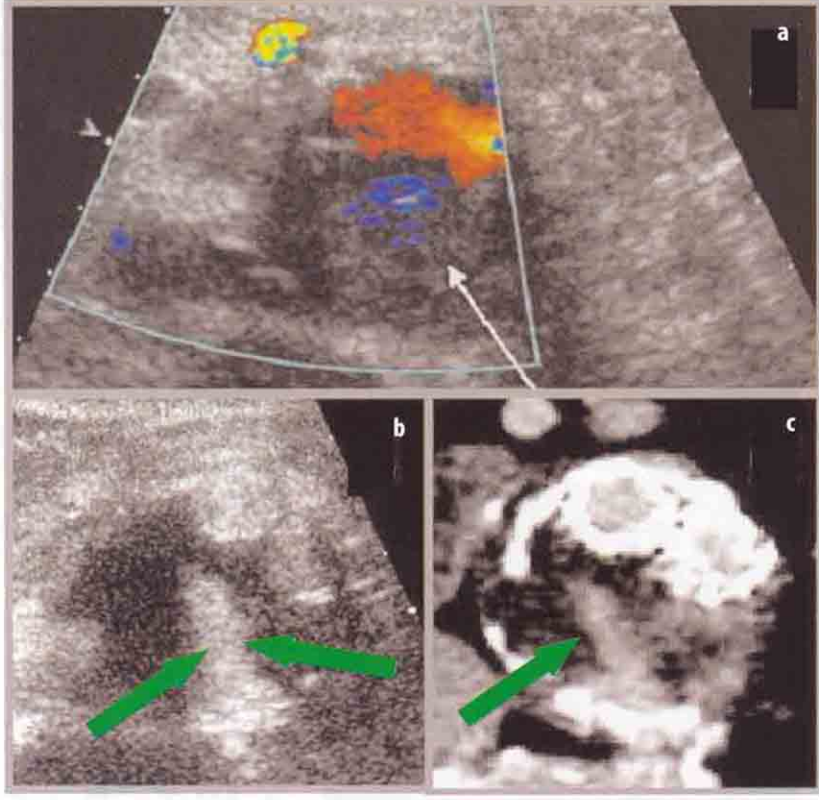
Type II Endoleak. a Transversal scan, colour Doppler. The aorto-iliac endovascular graft in the anterior part of the aneurysm is correctly patent; posteriorly, inside the residual thrombosed aneurysmatic sac, there is a chromatic signal (blue) (white arrow), which is not easily interpretable (possibly flow or artefact?). b Same, CEUS scans. In longitudinal (c) scan, the graft lumen is patent (hyperechoic); inside the residual sac, posteriorly to endoprosthesis a thin, hyperechoic, winding flow lumen (green arrows) is detectable (endoleak). c Angio-CT, transversal plane. Aneurysmatic walls are calcified. The metallic structure of the graft iliac branches are hyperdense and so their lumen. The leak is confirmed as a linear hyperdense image (green arrow), posteriorly located to the endovascular graft. There is a perfect overlapping between the flow phenomena depiction inside and outside the prosthesis of angio-CT and CEUS (b)
